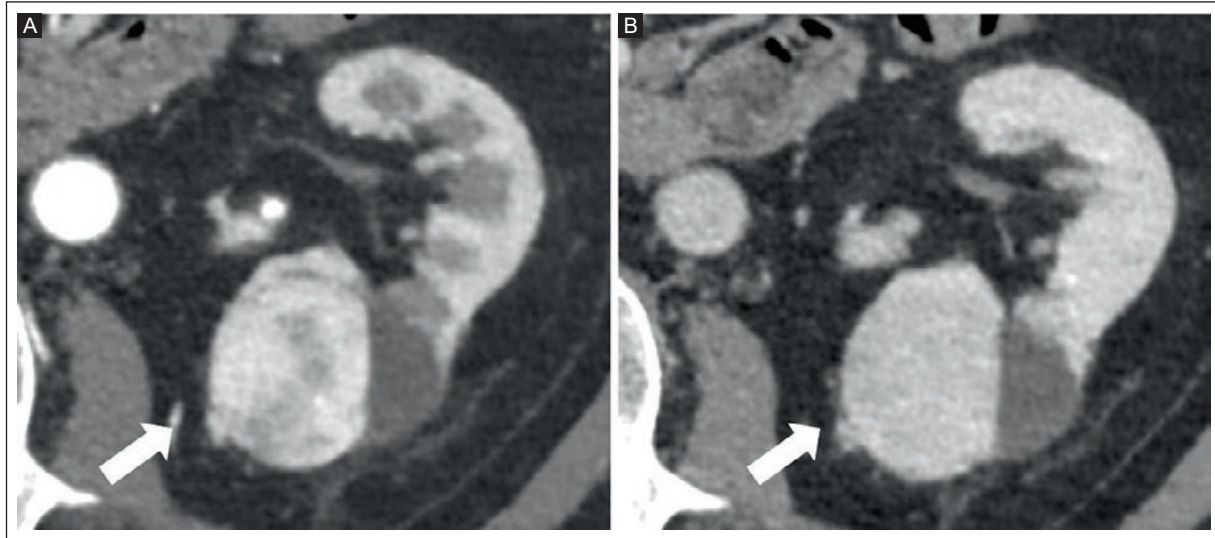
CT of an 84-year-old man with a left kidney oncocytoma. A: arterial phase, and B: portal phase show a well-defined expansile lesion with strong and homogeneous late enhancement (arrows).
